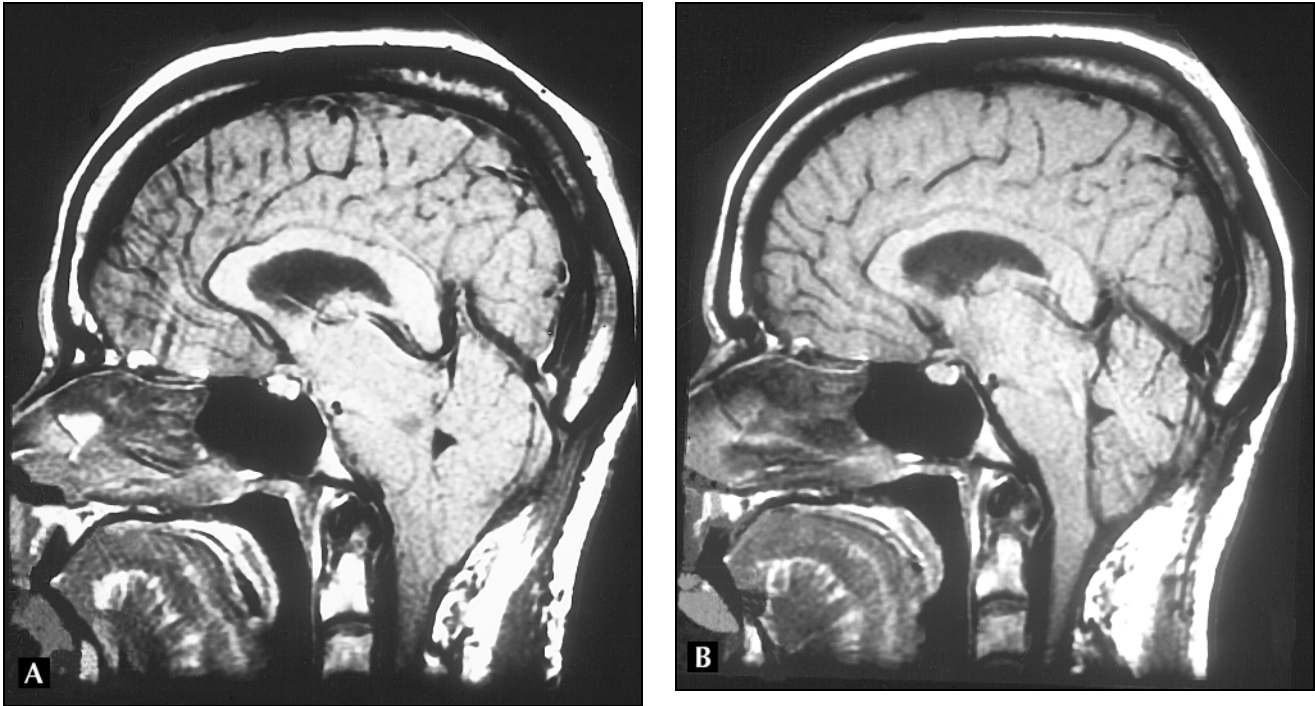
A, Same patient as shown in Figure 1. Magnetic resonance imaging sagittal view demonstrating descent of brain with crowding of the posterior fossa structures, resembling a Chiari type 1 malformation. B, Return to normal posterior fossa appearance with ascent of brain, following surgical repair of the cerebrospinal fluid leak. (From Lay *et al.* [18••]; with permission.)
